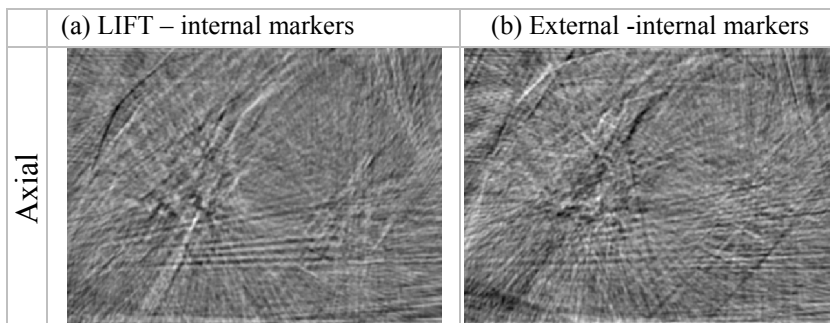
4D-CBCT Reconstruction from projection of Patient 4 sorted using different methods
